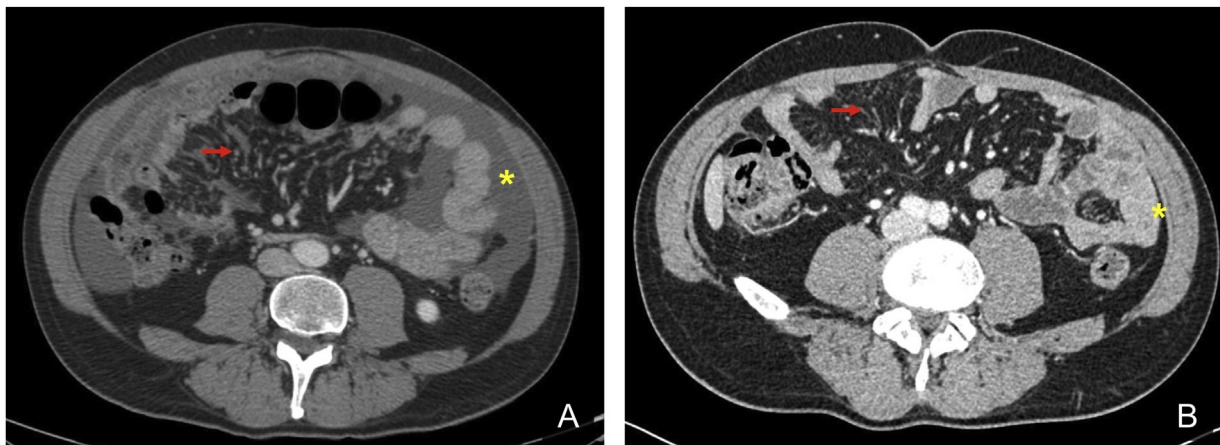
Abdomen CT scan before (A) and after (B) systemic chemotherapy with FOLFIRINOX. Red arrow: thickened mesenteric peritoneal surface (A) markedly reduced after treatment (B). Yellow asterisk: high volume ascites (A) disappeared after treatment (B).
